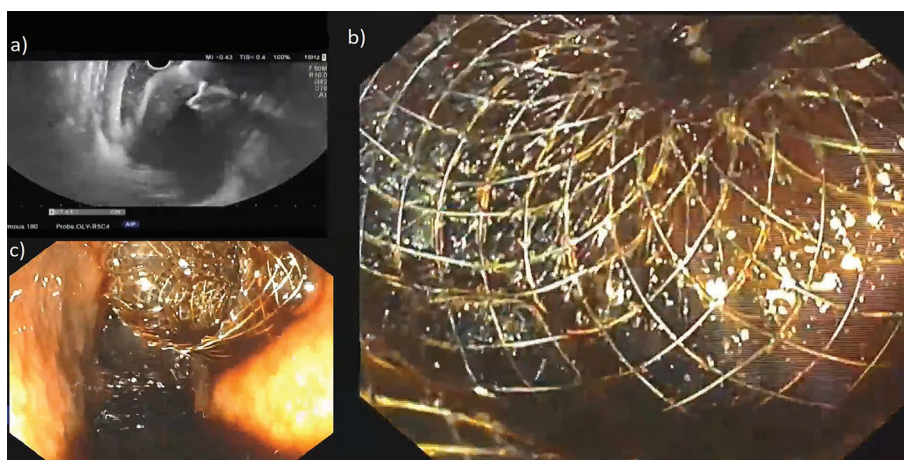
a) Endosonography image showing opened flange of self-expandable metal stent inside the collection (Hotaxios); b) Endoscopic view of intragastric flange of lumen apposing metal stent at deployment; c) Endoscopic view of intragastric lumen apposing metal stent after deployment showing exteriorization of dark brown fluid suggestive for pancreatic pseudocyst.
